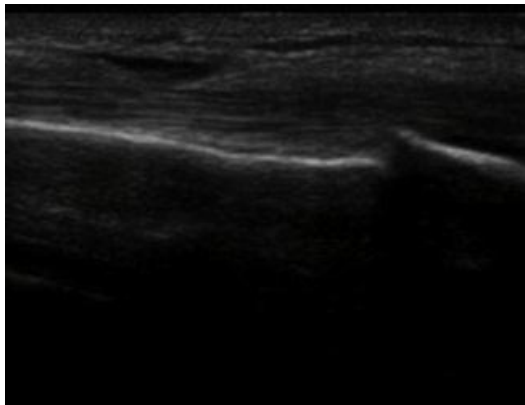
showing ultrasonic picture of distal radial fracture
